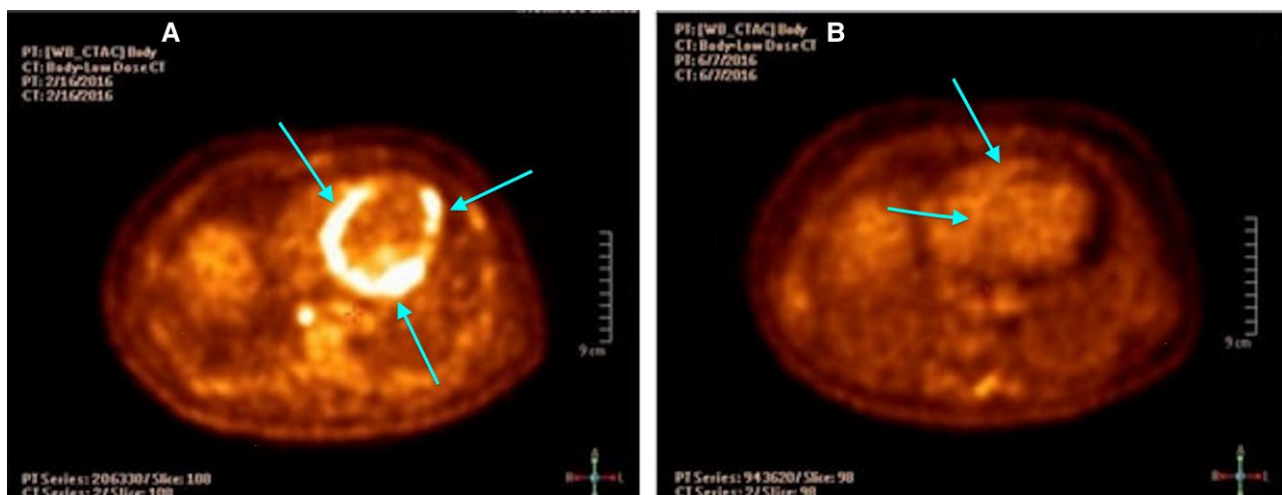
Coronal plane 18-FDG-PET images showing uptake before (A) and after (B) 5 months of corticosteroid therapy.
